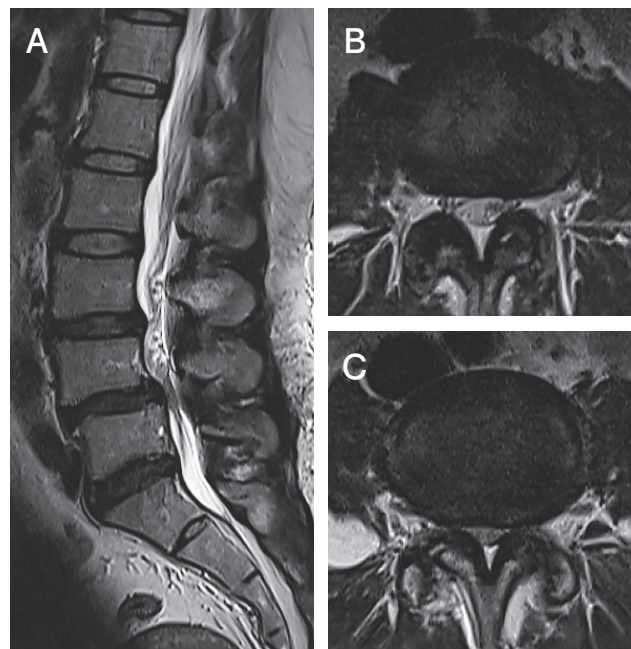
Preoperative MRI. The preoperative T2-weighted mid-sagittal image shows L4/5 stenosis. A, T2-weighted mid-sagittal image; B, T2-weighted axial view at L3/4 level; C, T2-weighted axial view at L4/5 level.
